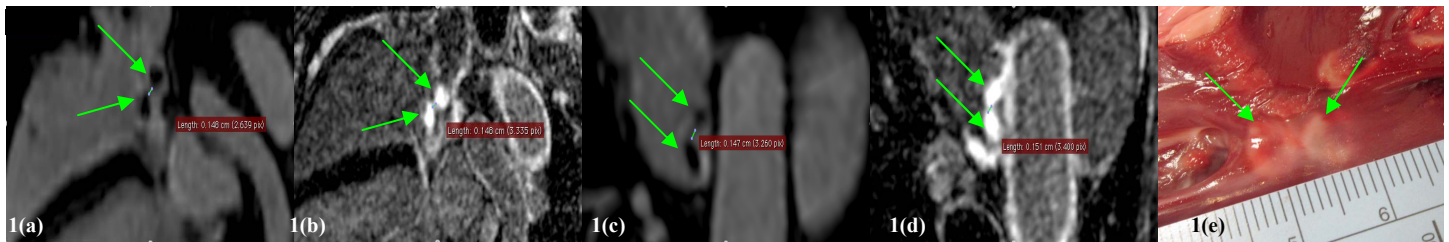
(a)-(e) Measurements of gap between ablation lesions in (a),(c) – Early LGE MRI (<7 mins post contrast injection); (b),(d) – Late LGE MRI (>75 mins post contrast injection); (e) Ex-vivo atrial tissue
